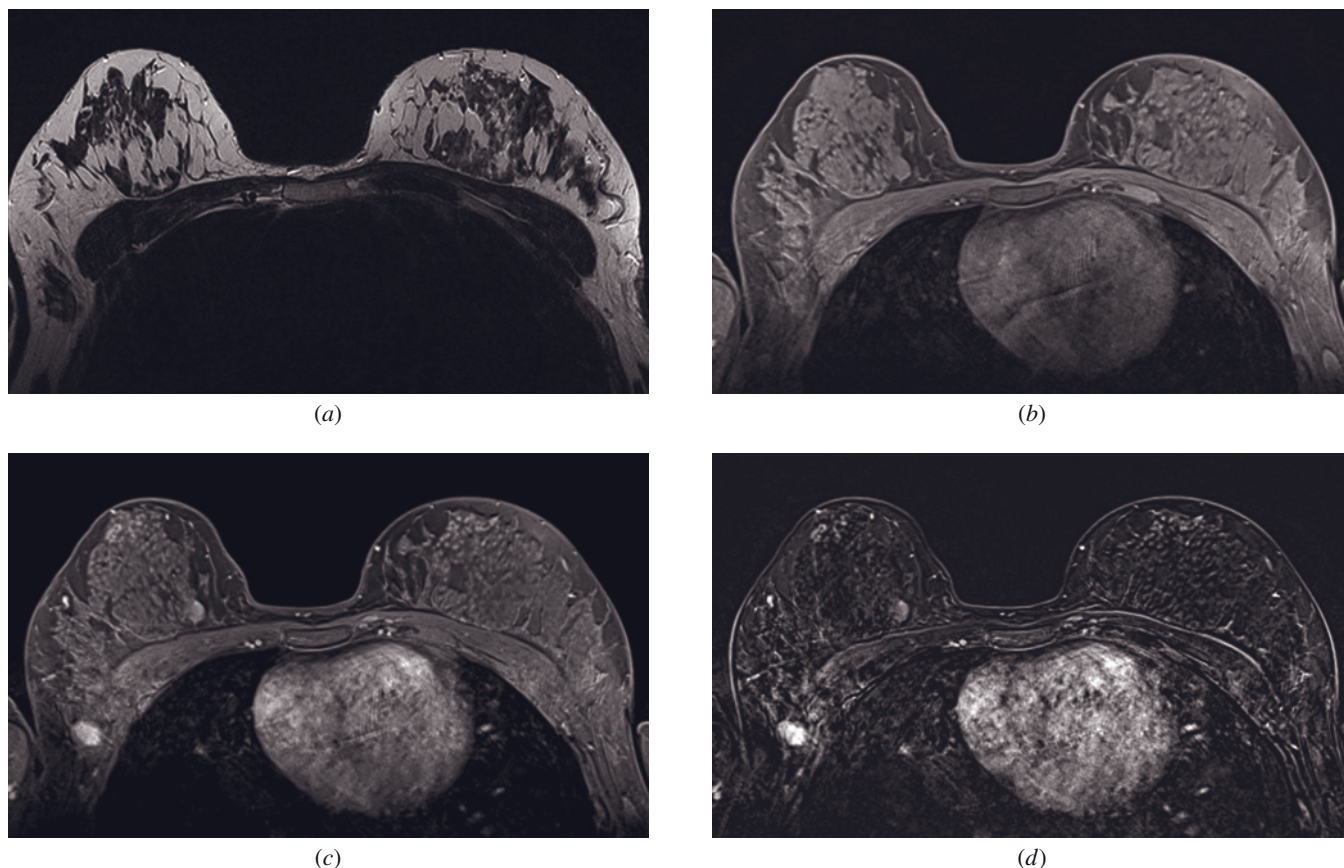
Fibroadenoma in accessory breast tissue. Axial T2-weighted (*a*) and dynamic GRE images (*b*) show breast asymmetry with accessory fibroglandular tissue in the axillary tail of the right breast. Axial postcontrast VIEWS (*c*) and subtracted (*d*) images reveal hyperintense lobulated mass located in the accessory tissue, with hypointense internal septations, characteristic for fibroadenoma.
